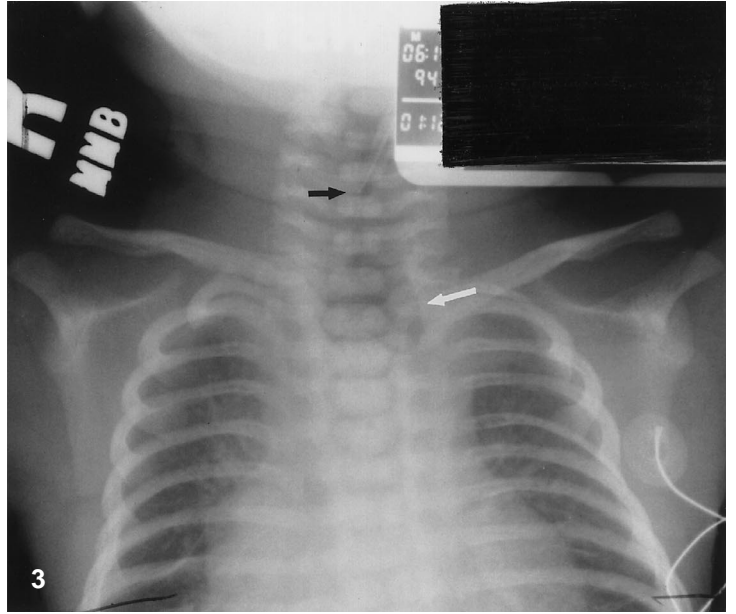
Anteroposterior radiograph of airway demonstrating moderate subglottic stenosis with (*arrow*) absence of normal subglottic “shouldering” in a 22-month-old girl
